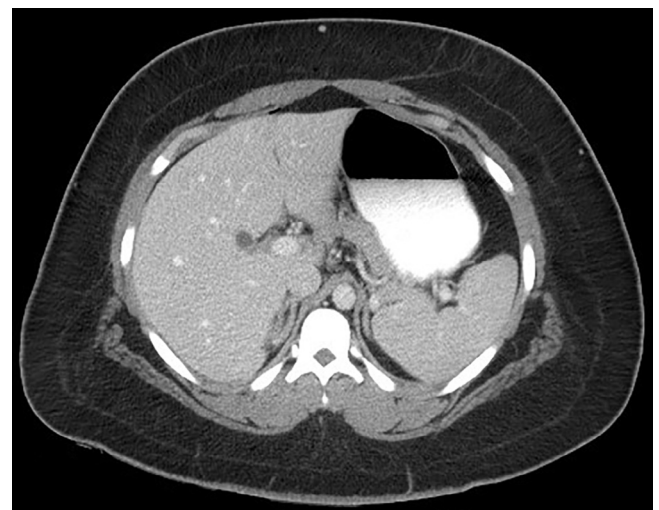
Axial view of computed tomography scan of abdomen and pelvis with contrast showing a small 9-mm structure in the gallbladder fossa likely related to gallbladder agenesis with no biliary obstruction and normal hepatic anatomy.
